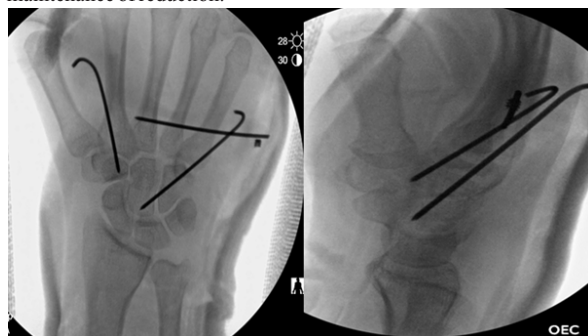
Intra operative radiographs showing reduced CMC joints and K wires in situ.
